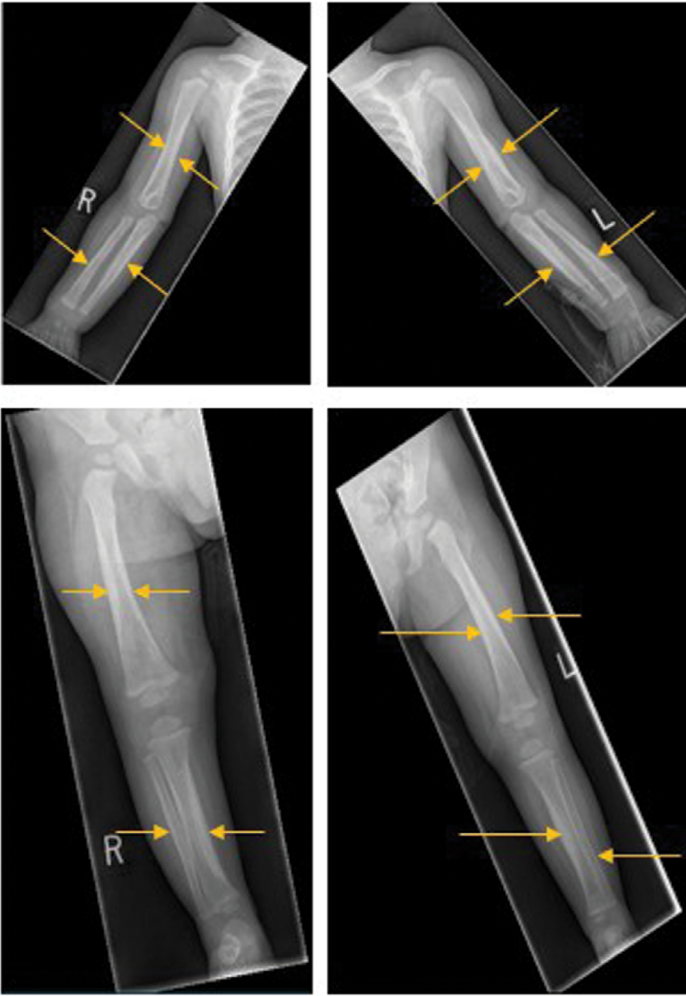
X-rays demonstrating findings of chronic osteitis involving all long bones of the upper and lower extremities (yellow arrows) in keeping with congenital syphilis
